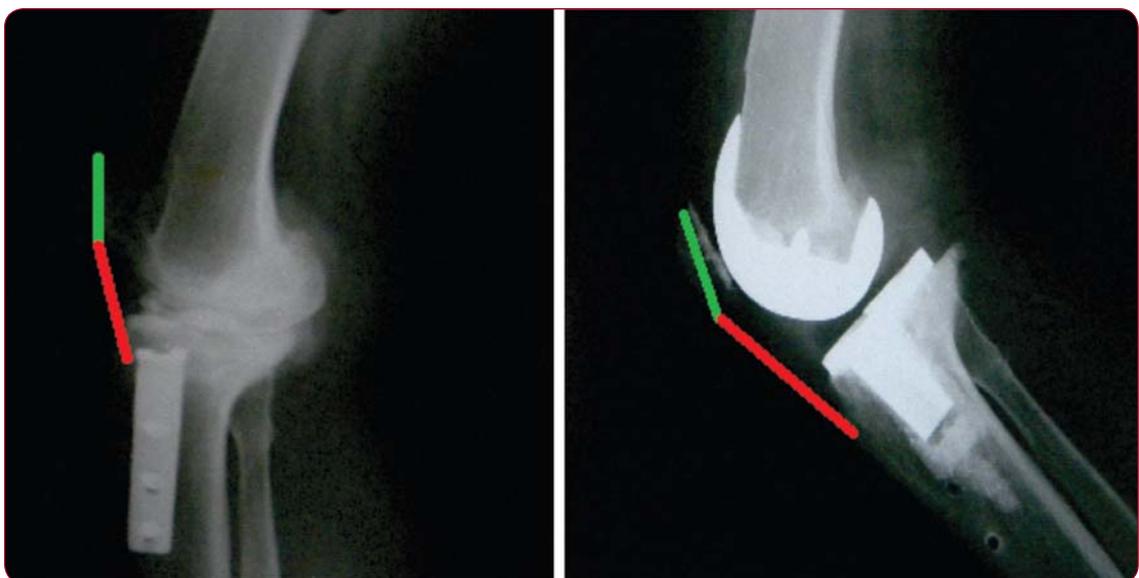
The ISR on the lateral view of the X-ray. The preoperative ISR is the ratio of the length of the patellar tendon to the length of the patella. The ISR at the last follow-up is the ratio of the length of patellar tendon to the length of the patella. Preoperative ISR and I SR at the last follow-up were compared
